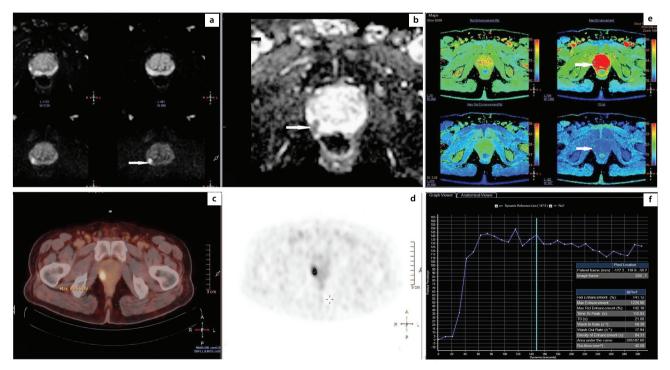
Peripheral zone with a PI-RADS 4 lesion, Gleason score 4 + 5, PSA: 5.72 µg/L, PSA-D: 0.23 ng/mL². (a) DWI (b = 0,600,1500 s/mm²) shows a marked hyperintense signal (arrow) above the background. (b) Apparent diffusion coefficient map reveals decreased signal intensity (arrow) in the lesion. (c, d) ⁽⁶⁸⁾Ga-PSMA-11 PET/CT images show avid uptake of radiotracer, with a SUV_{max} of 9.95. (e, f) DCE-MRI time-intensity curve demonstrates a decline after initial up-slope enhancement. TTP: 115.93 s⁻¹; wash-in rate; 58.28 s⁻¹, wash-out rate; 17.94 s⁻¹. PI-RADS, Prostate Imaging–Reporting and Data System; PSA, prostate-specific antigen; DWI, diffusion-weighted imaging; PSMA, prostate-specific membrane antigen; PET, positron emission tomography; CT, computed tomography; SUV_{max}, maximum standardized uptake value; DCE, dynamic contrast-enhanced; MRI, magnetic resonance imaging.
